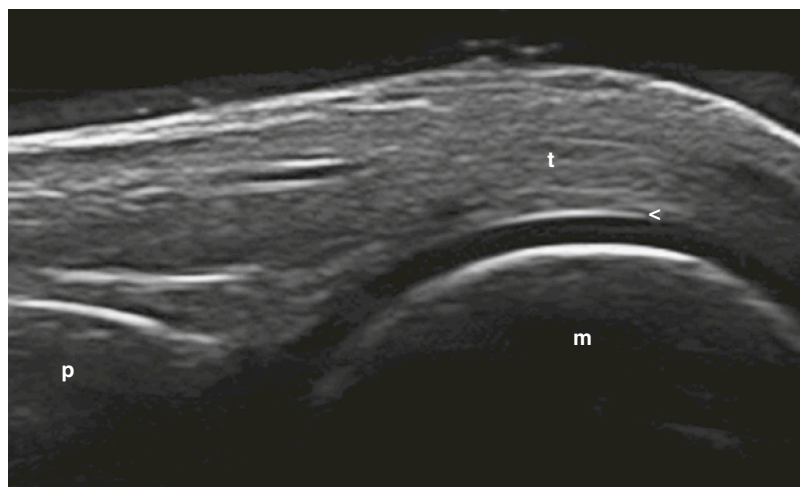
NORMAL HAND. Longitudinal dorsal view shows the metacarpophalangeal joint in maximal flexion and typical sonographic features of the normal hyaline cartilage. Perpendicular insonation of the cartilage surface allows for the correct visualization of the superficial margin, which appears as a subtle hyperechoic line about 0.1 mm thick (*arrowhead*). m, metacarpal head; p, proximal phalanx; t, extensor tendon.
